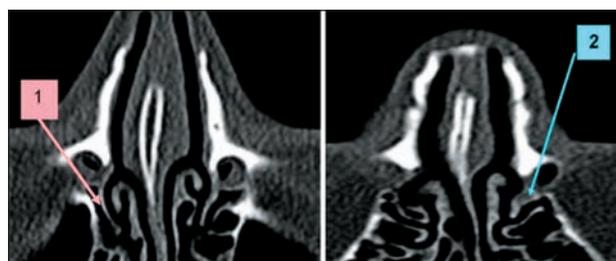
Paranasal sinuses CT scan, bone window, axial slices: 1. curved uncinatoprocess, with "hook" extremity deformation; 2. deformation and thickening of the the left uncinatoprocess
